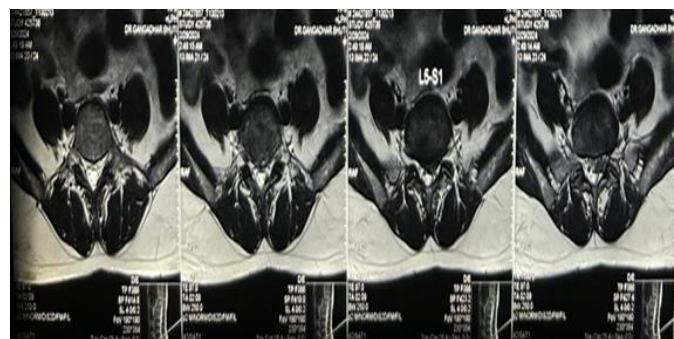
Axial sections of MRI
